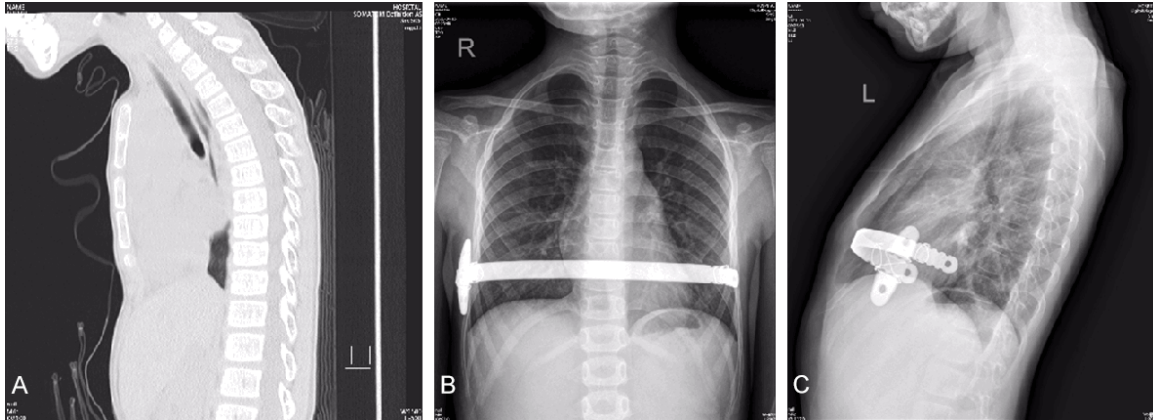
Contrast radiographs of a 6-year-old child before and after surgery. A: Before the operation; B: 1 month after the operation; C: 3 months after the operation.
